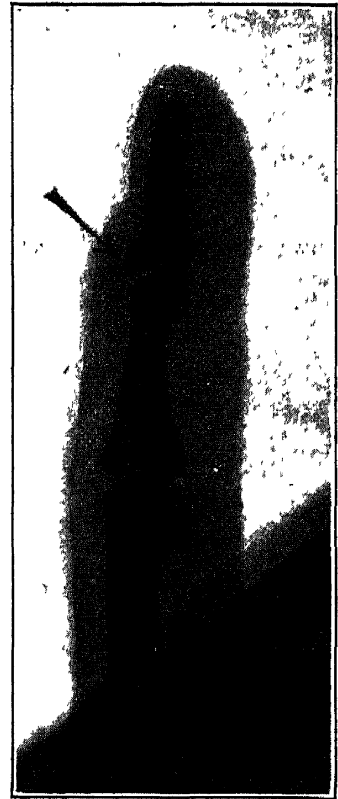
RADIOGRAPH OF TRAUMATIC DROP-FINGER, LATERAL VIEW. Same patient as Fig. 170.
